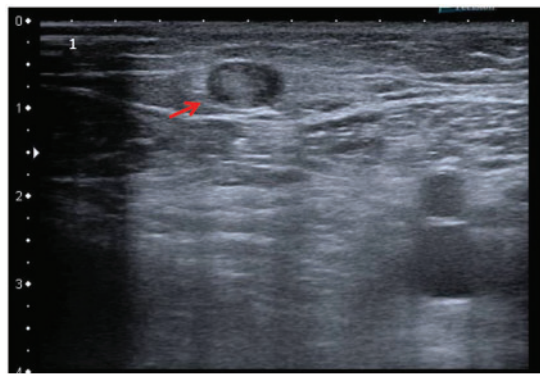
Doppler ultrasound showing a left saphenous obstructive superficial venous thrombosis. Red arrow pointing at the venous thrombosis.
